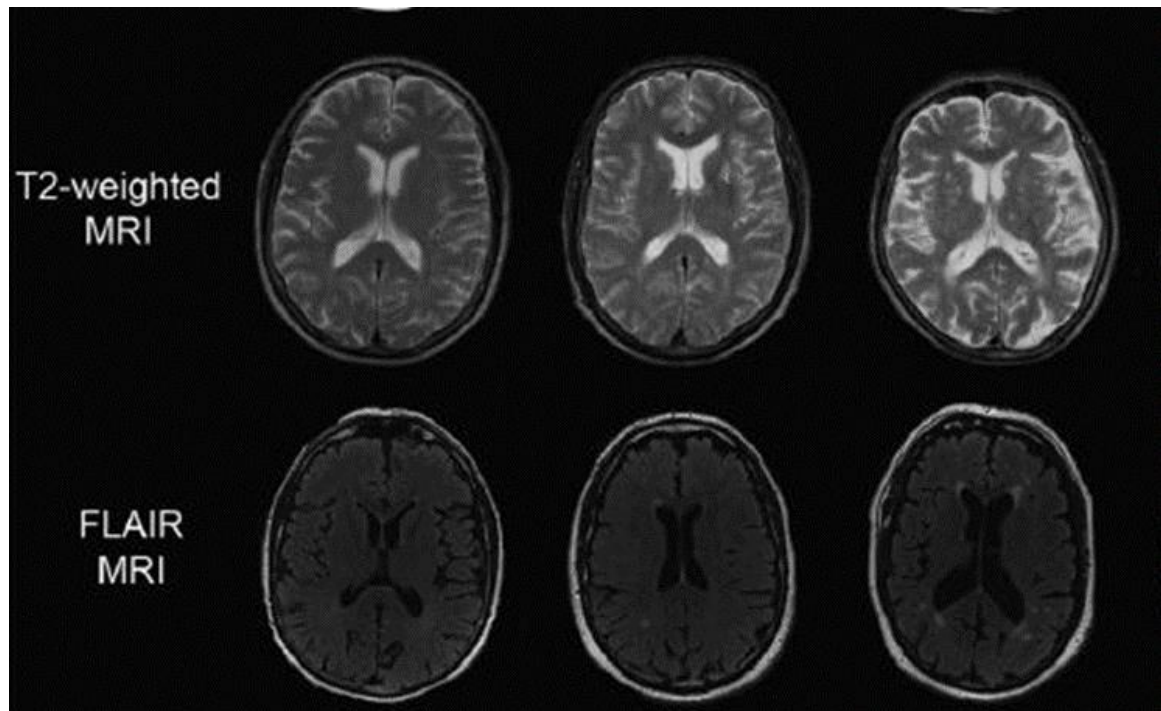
Leukoaraiosis on T2WI and FLAIR sequence appear hyperintense on MRI
